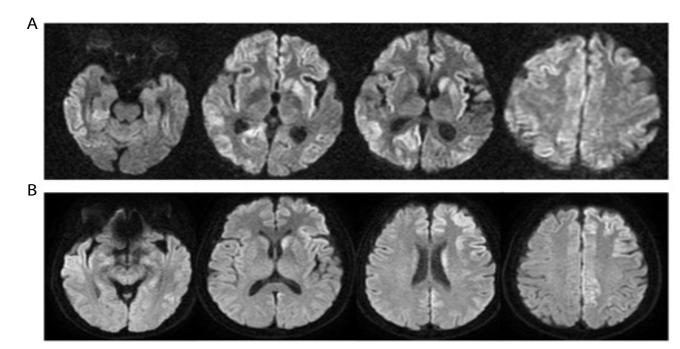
(A) In the case 1, DWI demonstrated diffuse cortical ribbon signs and hyperintensities involving bilateral caudate nuclei and left putamen. (B) In the case 2, DWI depicted hyperintensities involving left caudate nucleus, left parietal and frontal, and right insular and temporal areas.
